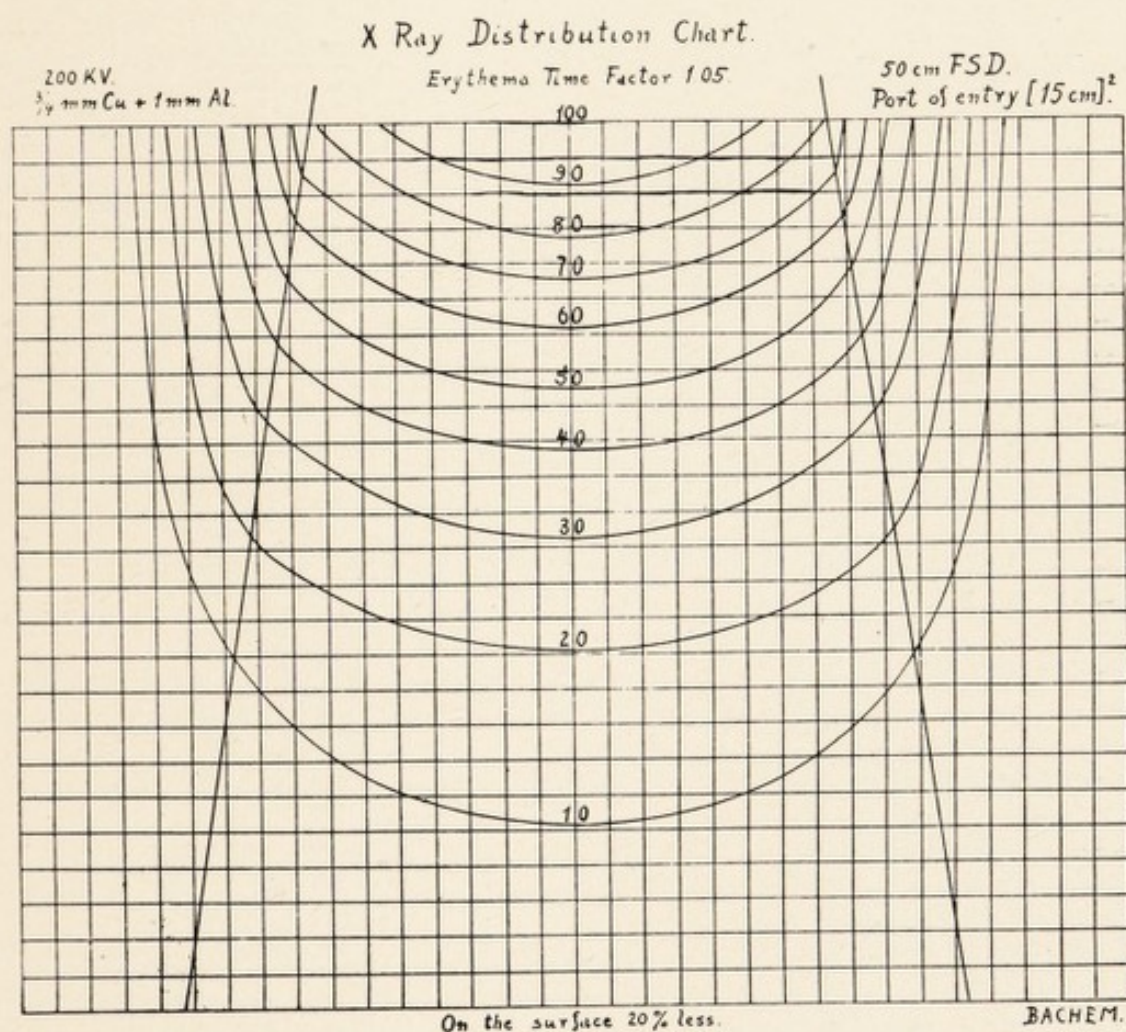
X-RAY EQUAL INTENSITY CURVES IF PORT OF ENTRY IS 15 CM.<sup>2</sup>
